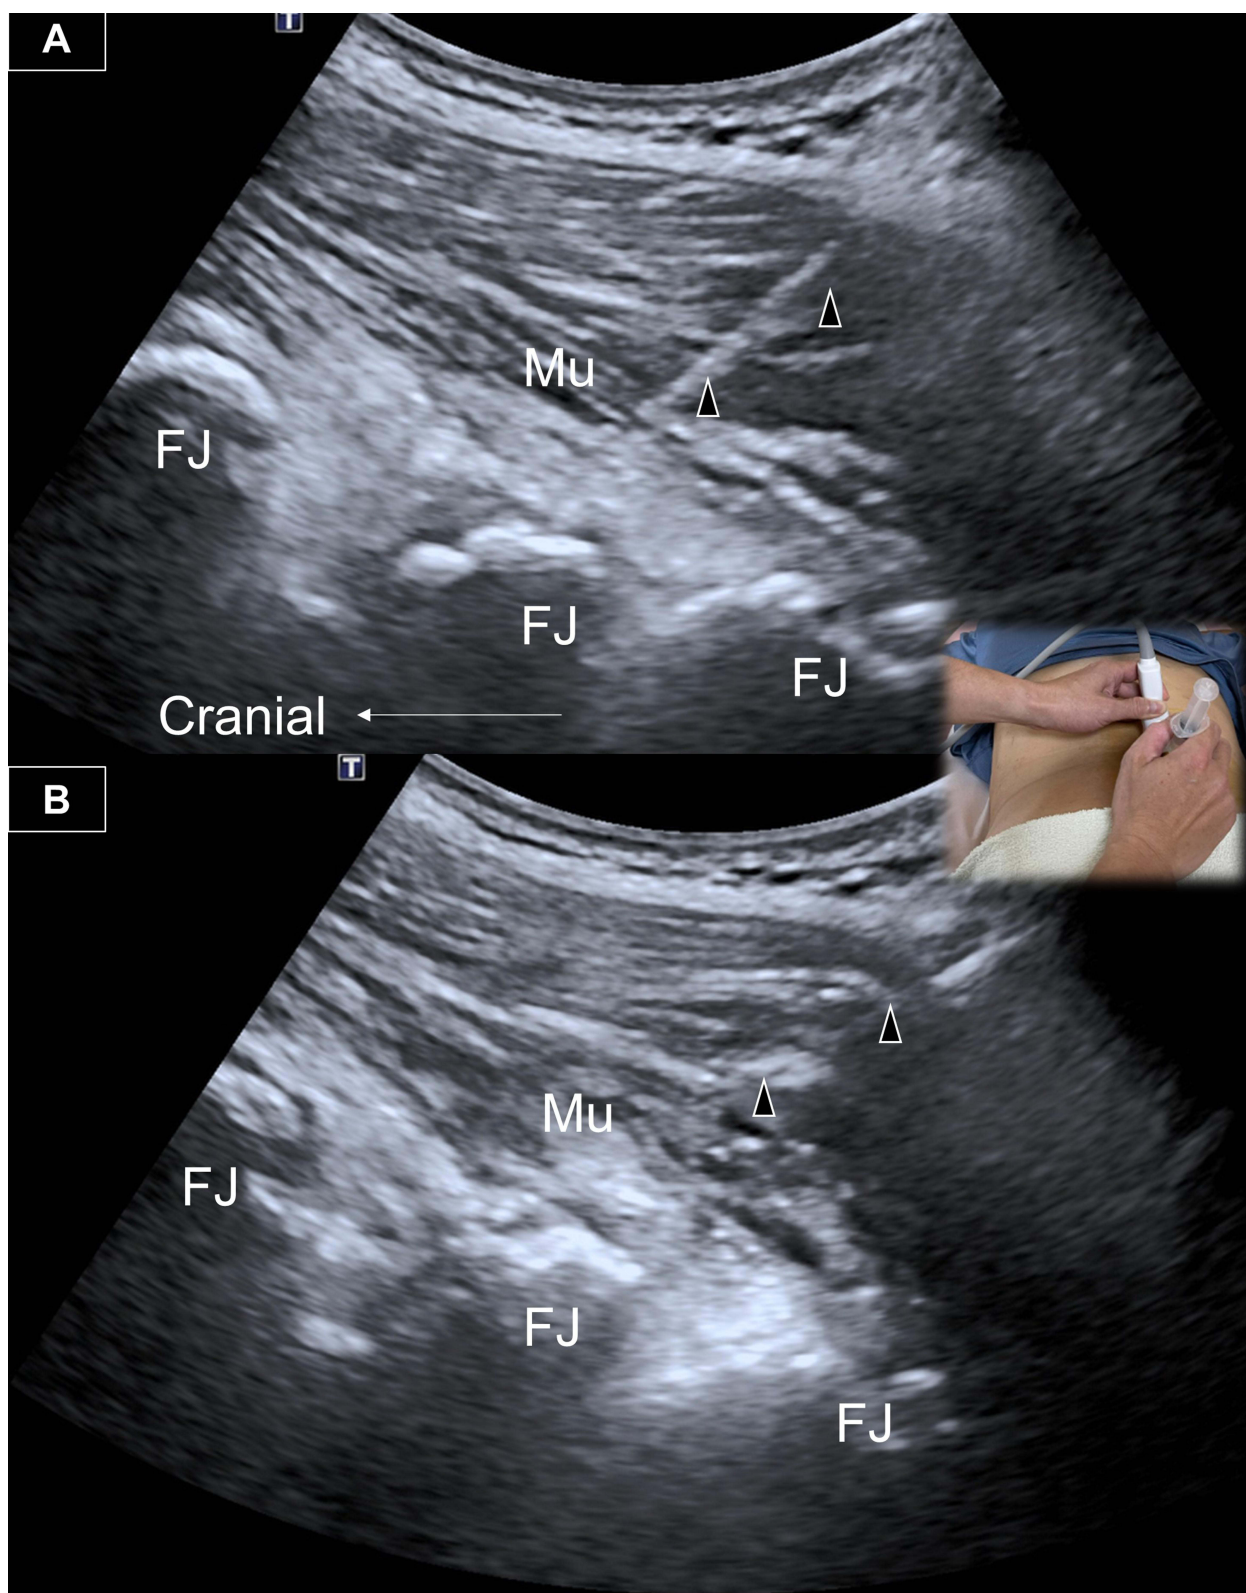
Ultrasound-guided (A) lumbar facet joint (FJ) and (B) lumbar multifidus (Mu) muscle injection. Arrowhead, needle trajectory.
